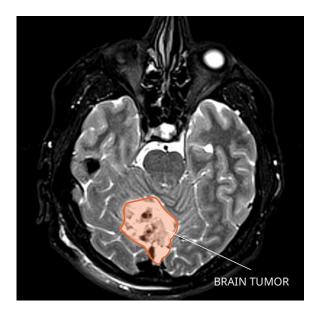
A transverse section of a Magnetic Resonance Image (MRI) scan of a pediatric brain. The highlighted portion indicates a Medulloblastoma mass originating from the cerebellum ⁽⁵⁾
